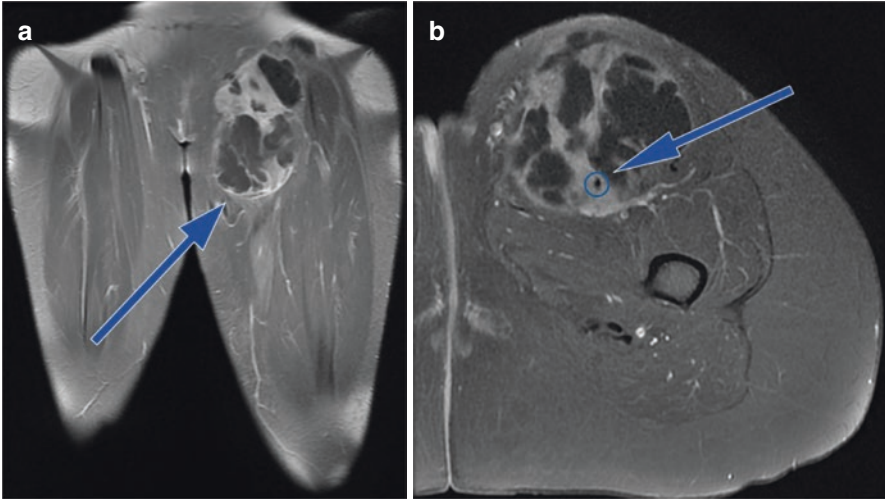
(a) T2-weighted magnetic resonance coronal section showing anterior thigh sarcoma. (b) T2-weighted magnetic resonance axial section showing femoral artery involvement by the sarcoma
